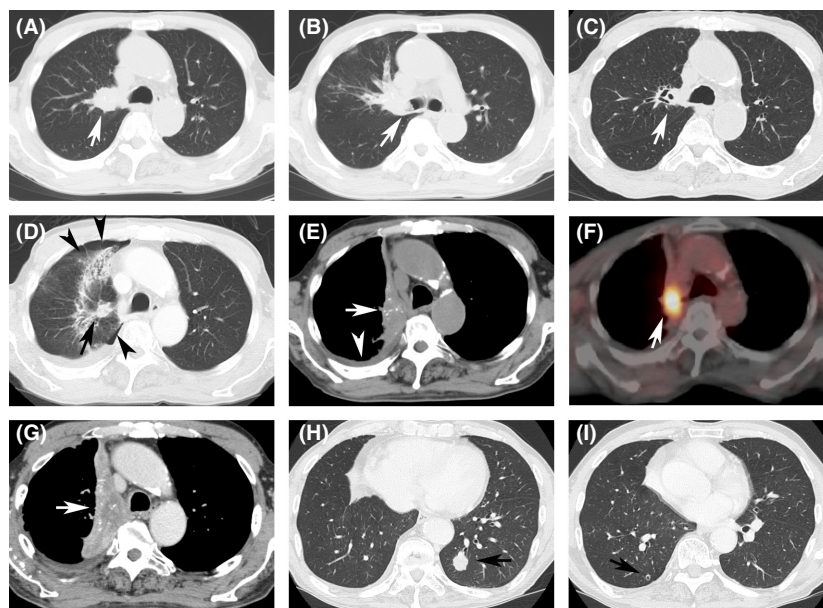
Chest computed tomography (CT) scan. (A) A tumor (2.4 cm in diameter, arrow) is present at the right hilar area. (B) The tumor is distended into the right main bronchus (arrow). (C) The tumor (arrow) is reduced in size after concurrent chemoradiotherapy, after 3 months of beginning of the treatment. (D) Reticular interstitial processes with small pneumothoraces (arrowheads) and the tumor (1.5 cm in diameter, arrow). (E) Atelectasis (arrow) with the right pleural effusion (arrowhead). The tumor and atelectasis are iso-density. (F) PET/CT scan shows strong ¹⁸F-fluorodeoxyglucose uptake (arrow) at the right hilar area. (G) Atelectasis with the right pleural effusion. The tumor (arrow) is slightly bigger compared to (E). (H, I) Intrapulmonary metastases (arrow).
